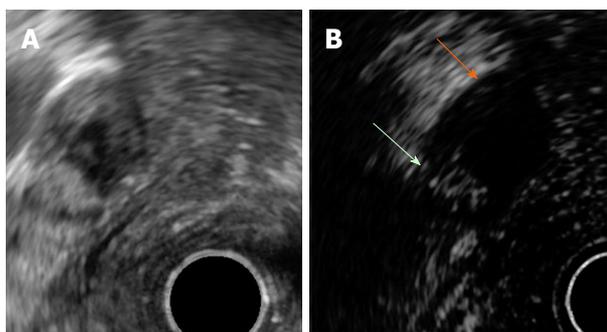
Mural nodule and mucus in branch duct type intraductal pancreatic mucinous neoplasms. A: EUS B mode image. B: Contrast harmonic EUS image. Microbubbles in a mural nodule (green arrow). No bubbles in a mucus clot (orange arrow). EUS: Endoscopic ultrasonography.
